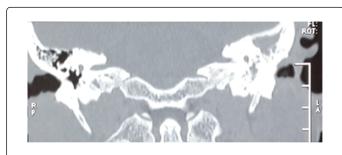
CT reveals confluent areas of the left mastoid.
